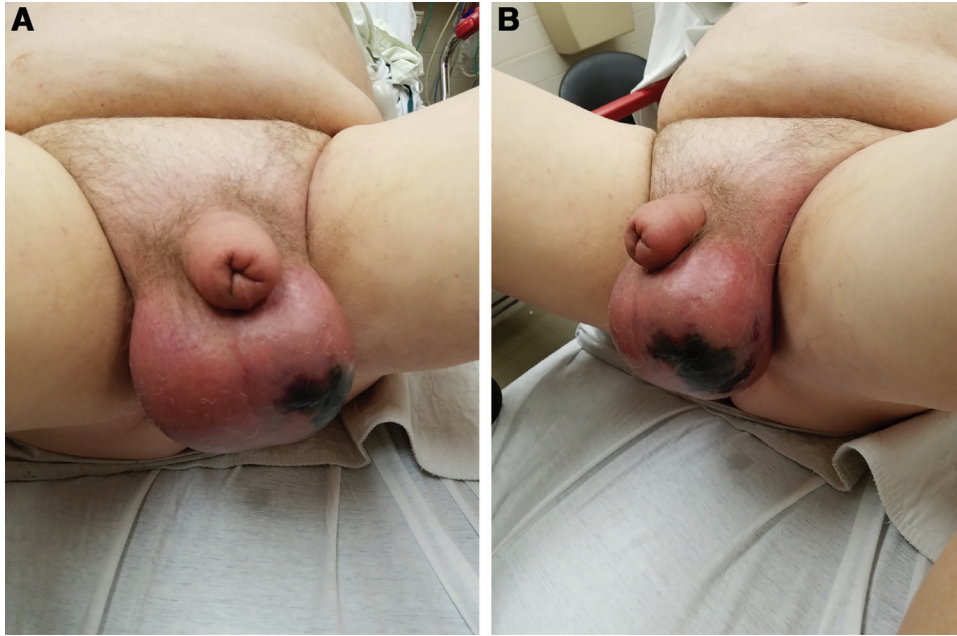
Wound appearance on the day of initial presentation with Fournier's gangrene infection. The patient was 75 years old with a history of hypertension and hyperlipidemia who presented with 3 days of scrotal pain and swelling. Workup demonstrated a leukocytosis of 12.9, elevated lactic acid at 4.2, hyponatremia to 131, hyperglycemia of 199 with periscrotal subcutaneous gas evident on CT (computed tomographic) pelvis imaging. The patient was taken for emergent surgical debridement after this picture was obtained.
